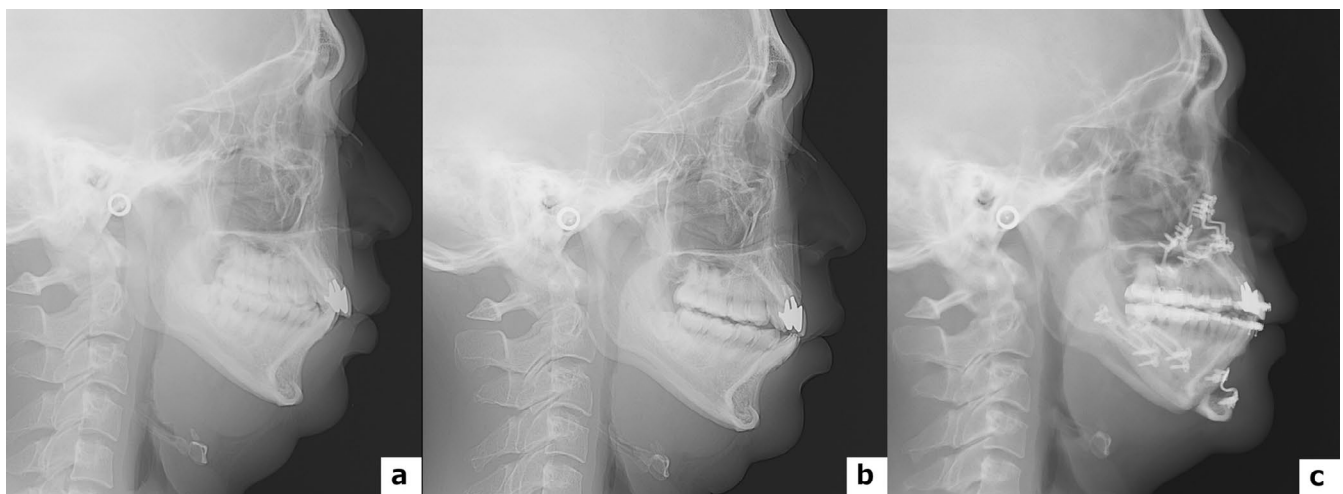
Cephalometric radiographs. (a) Before treatment. (b) After oral appliance treatment. (c) After sleep surgery (6 month).
